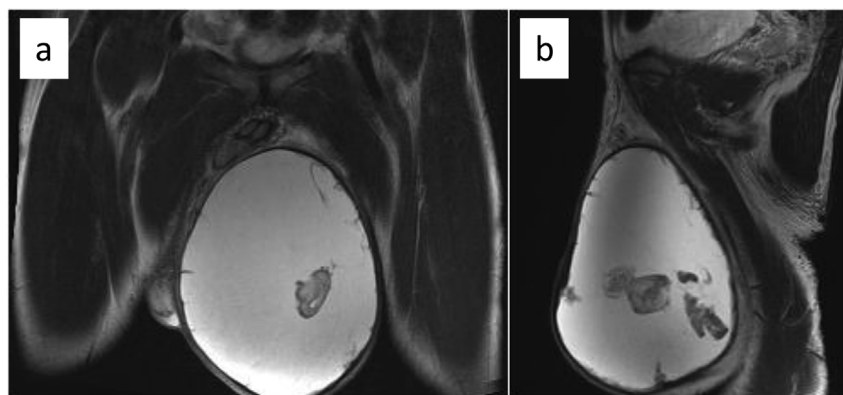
T2-weighted MRI of the left scrotum (a: coronal image, b: sagittal image). The fluid content showed high intensity related to hemorrhage. The irregular-shaped nodular structure with low intensity floating in the fluid was suggestive of blood clots.
